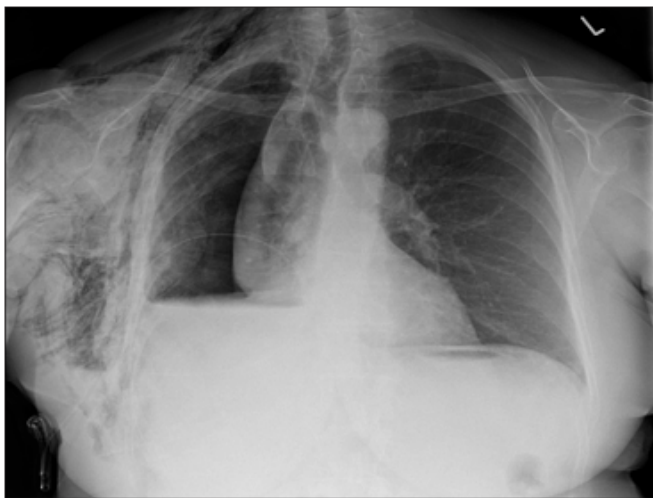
Changes on chest radiograph.
